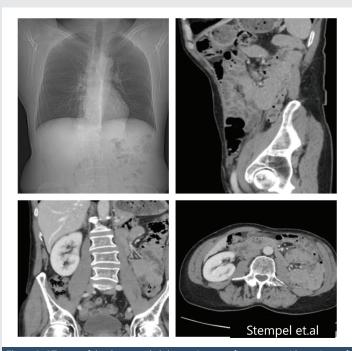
CT-scan of the thorax and abdomen 9-years after surgery with no signs of local recurrence or metastases.
